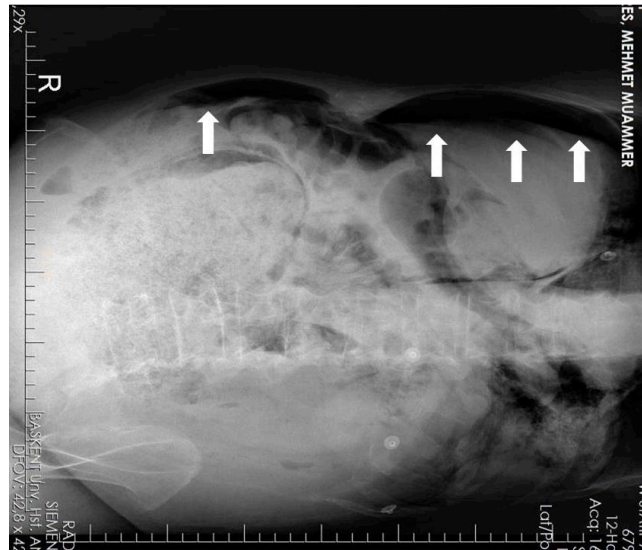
Lateral decubitus abdominal X-ray
